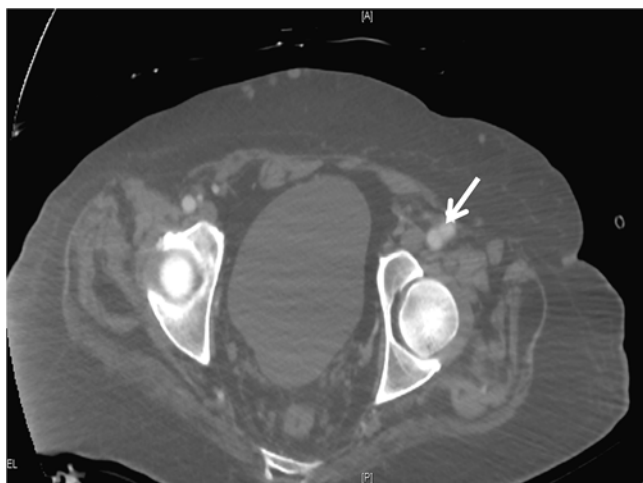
CT scan with contrast showing a common femoral artery pseudoaneurysm (arrow)
